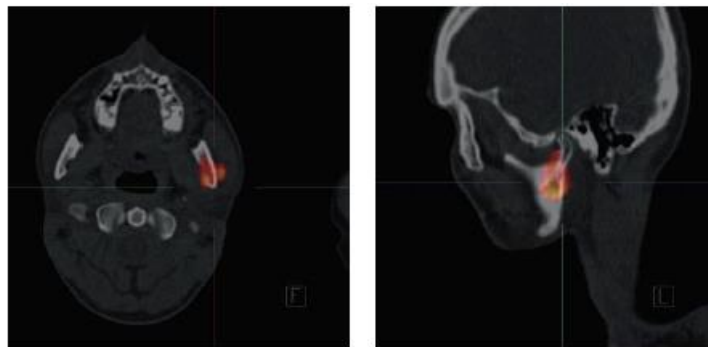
18F-FDG PET-CT scan demonstrating increased uptake in primary lymphoma of the left mandibular ramus and left masseter muscle. (a) Axial image, (b) coronal slice (the images are reproduced courtesy of Prof. Leszek Królicki, Head of the Department of Nuclear Medicine of the Medical University of Warsaw, Poland)^[61]
